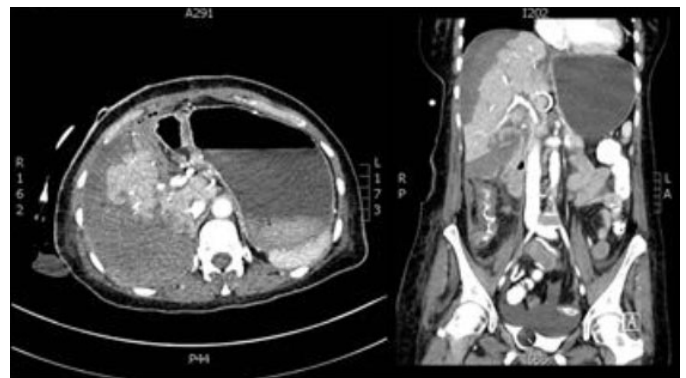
CT venous phase scan of abdomen showing extensive hepatic necrosis involving segments 6 and 7 and also peripheral areas of segments 8 and 5—Week 3.
